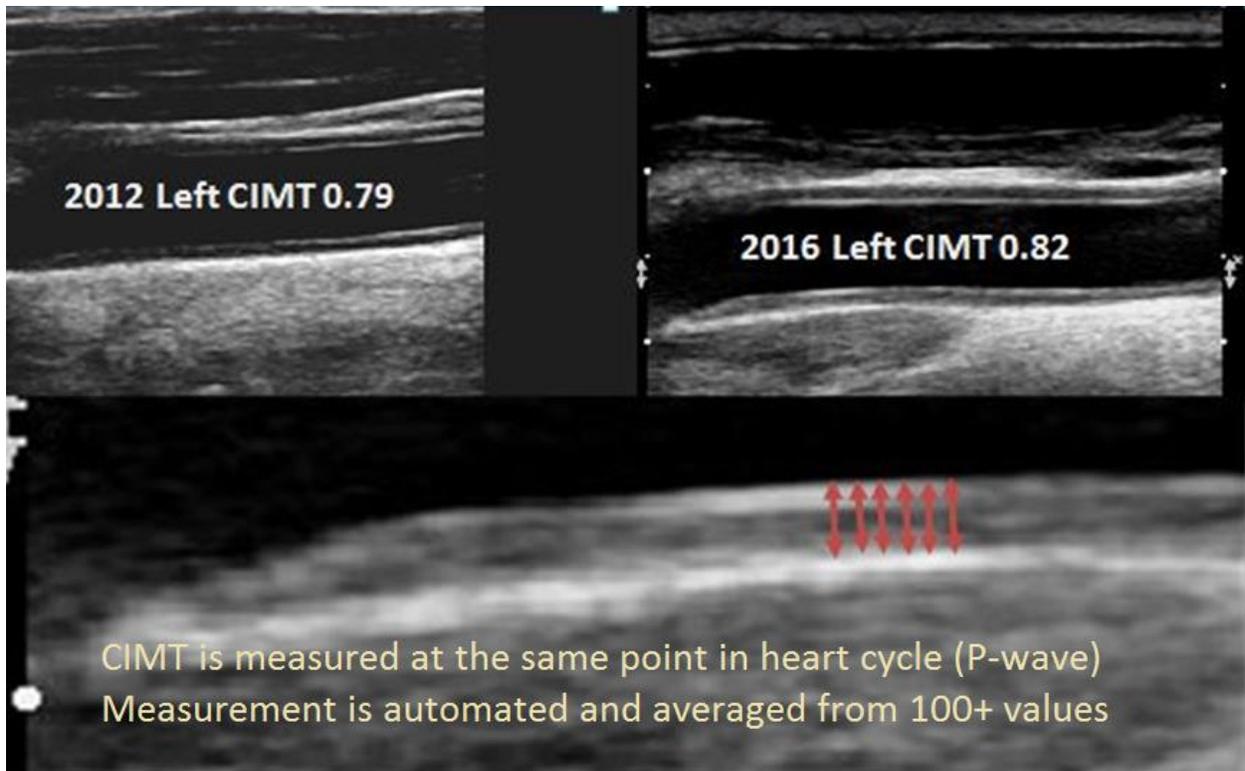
Carotid intima media thickness measurement performed by ultrasound.
